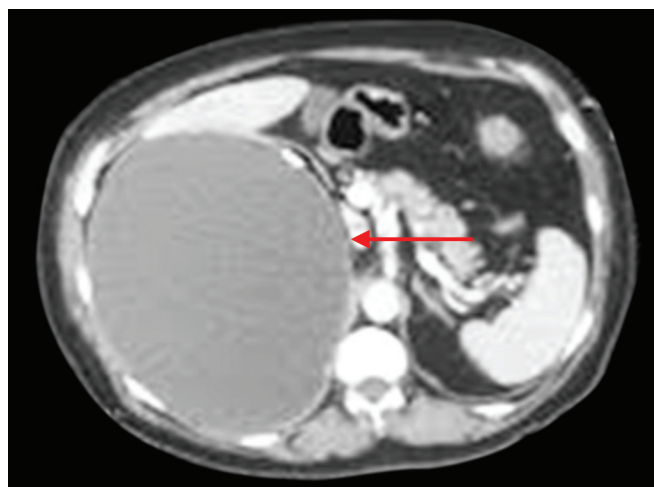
Computed tomography of abdomen showing homogeneously hypodense mass (red arrow marking adrenal cyst) in the right adrenal gland
